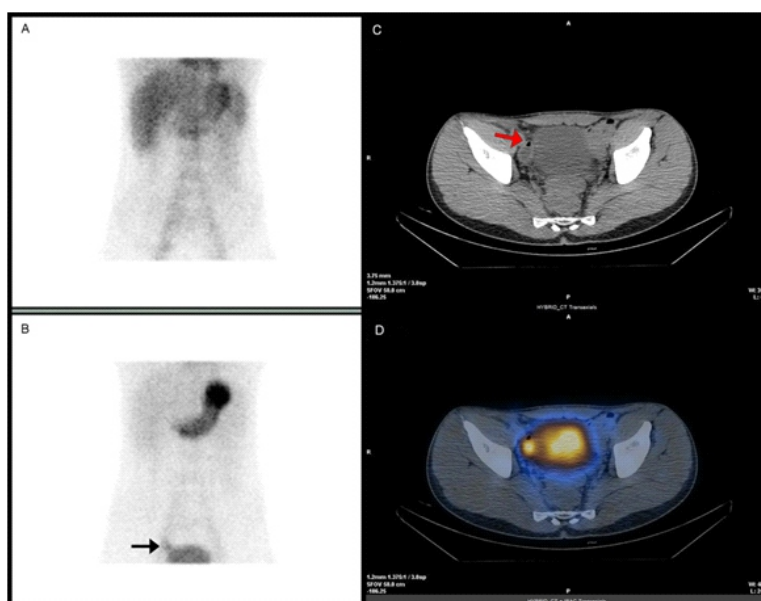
A 23-year-old male presented with black stools and several painless episodes of active intestinal bleeding. Sequential planar images 5min (A) and 20min (B) following the intravenous administration of 185MBq (5mCi) of ^{99m}Tc -pertechnetate demonstrated a subtle focal uptake in the right iliac fossa, next to the urinary bladder (black arrow). Imaging characteristics supported the diagnosis of either Meckel's diverticulum or bladder diverticulum. Axial CT (C) and SPECT/CT hybrid images (D) revealed the exact anatomical localization of the focal uptake, within the pelvic region, next to the right margin of the bladder. Moreover, SPECT/CT was the key method for the differential diagnosis since the low-dose CT demonstrated the presence of air within the lesion of radiotracer uptake (red arrow). This finding was suggestive of an abnormal bulging pouch of the bowel, not the bladder, and consistent with Meckel's diverticulum.
